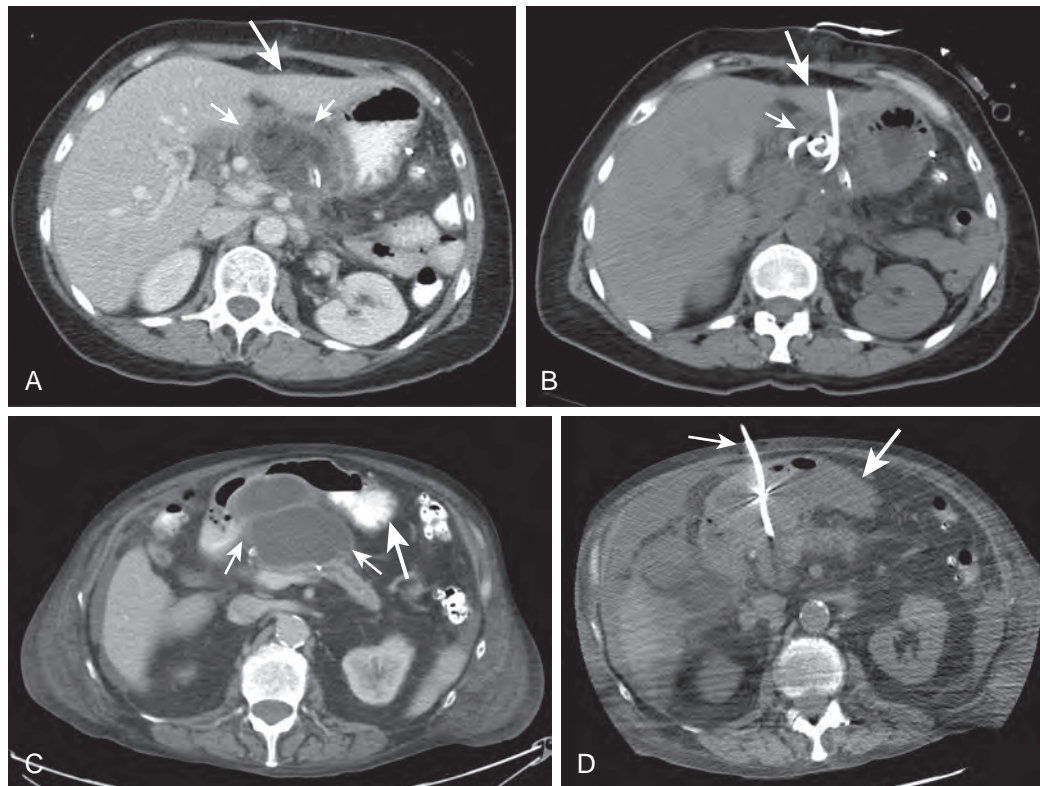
Organ traversal technique for percutaneous abscess drainage. A. Contrast-enhanced axial CT image shows an abscess (*thin arrows*) posterior to the left lobe of the liver (*thick arrow*). B. Percutaneous abscess drainage was performed with successful placement of the drainage catheter into the abscess (*thin arrow*) after traversing the lateral portion of the left lobe of the liver (*thick arrow*). C. Contrast-enhanced axial CT image shows a bilobed infected pancreatic pseudocyst (*thin arrows*). The drainage catheter is indicated by the thin arrow. D. Percutaneous drainage of this abscess necessitated traversal of the stomach (*thick arrow*). The stomach is indicated by the thick arrow.
